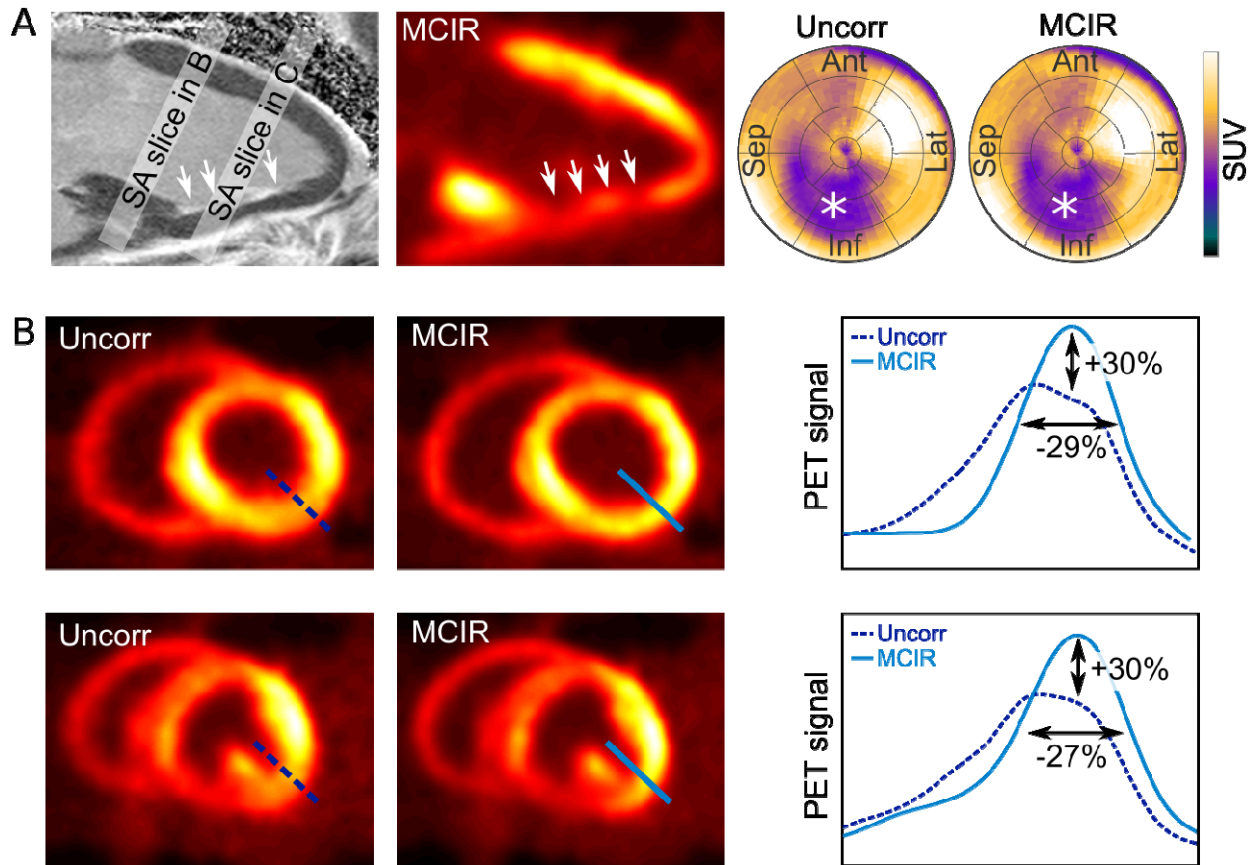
Results of in-vivo PET scans. A Delayed enhancement (DE) 2-chamber MR image showing fibrotic tissue in the inferior part of the left ventricle (white arrows). This area also shows low myocardial FDG uptake. Bulls-eye plots show the low uptake region clearly (*) in the uncorrected (uncorr) and cardiac motion corrected (MCIR) PET images. (B) Basal and mid-ventricular short-axis (SA) PET motion corrupted and MCIR slices. Cardiac motion leads to strong blurring of the myocardial uptake in the posterior area of the ventricle. MCIR can correct for that leading to an increase in signal amplitude of 30% and an improvement of full-width-at-half-maximum of 29%.
